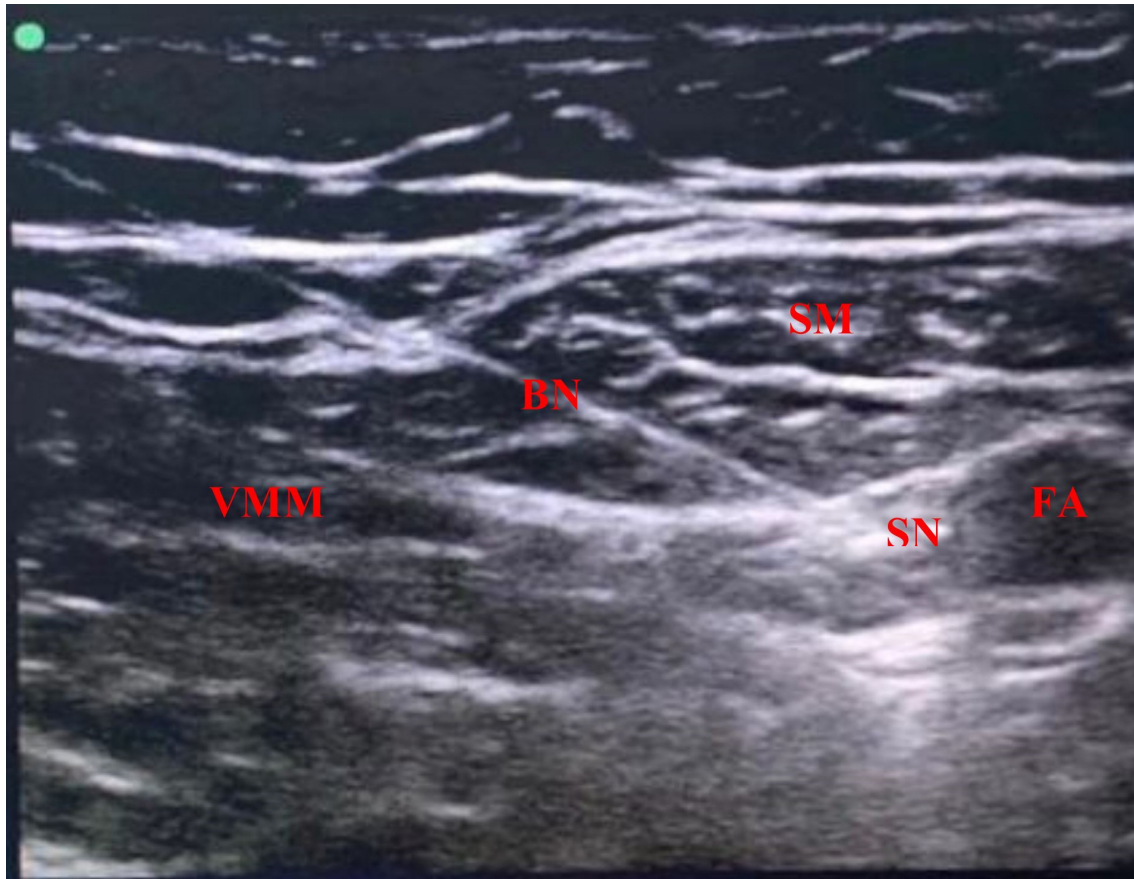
Adductor Canal Block; Ultrasound Anatomy. BN, block needle; SN, saphenous nerve; FA, femoral artery; SM, sartorius muscle; VMM, vastus medialis muscle.
